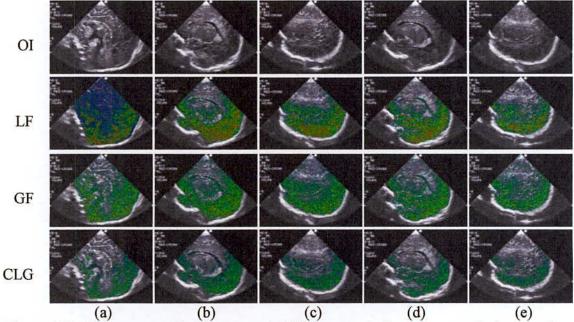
Ultrasonographic images of different sagittal sections and the overlapped frequency pulsation images using different optical flow optimization are shown. (a) Midline sagittal (b) Lateral sagittal left (c) Most Lateral sagittal left (d) Lateral sagittal right (e) Most Lateral sagittal right
